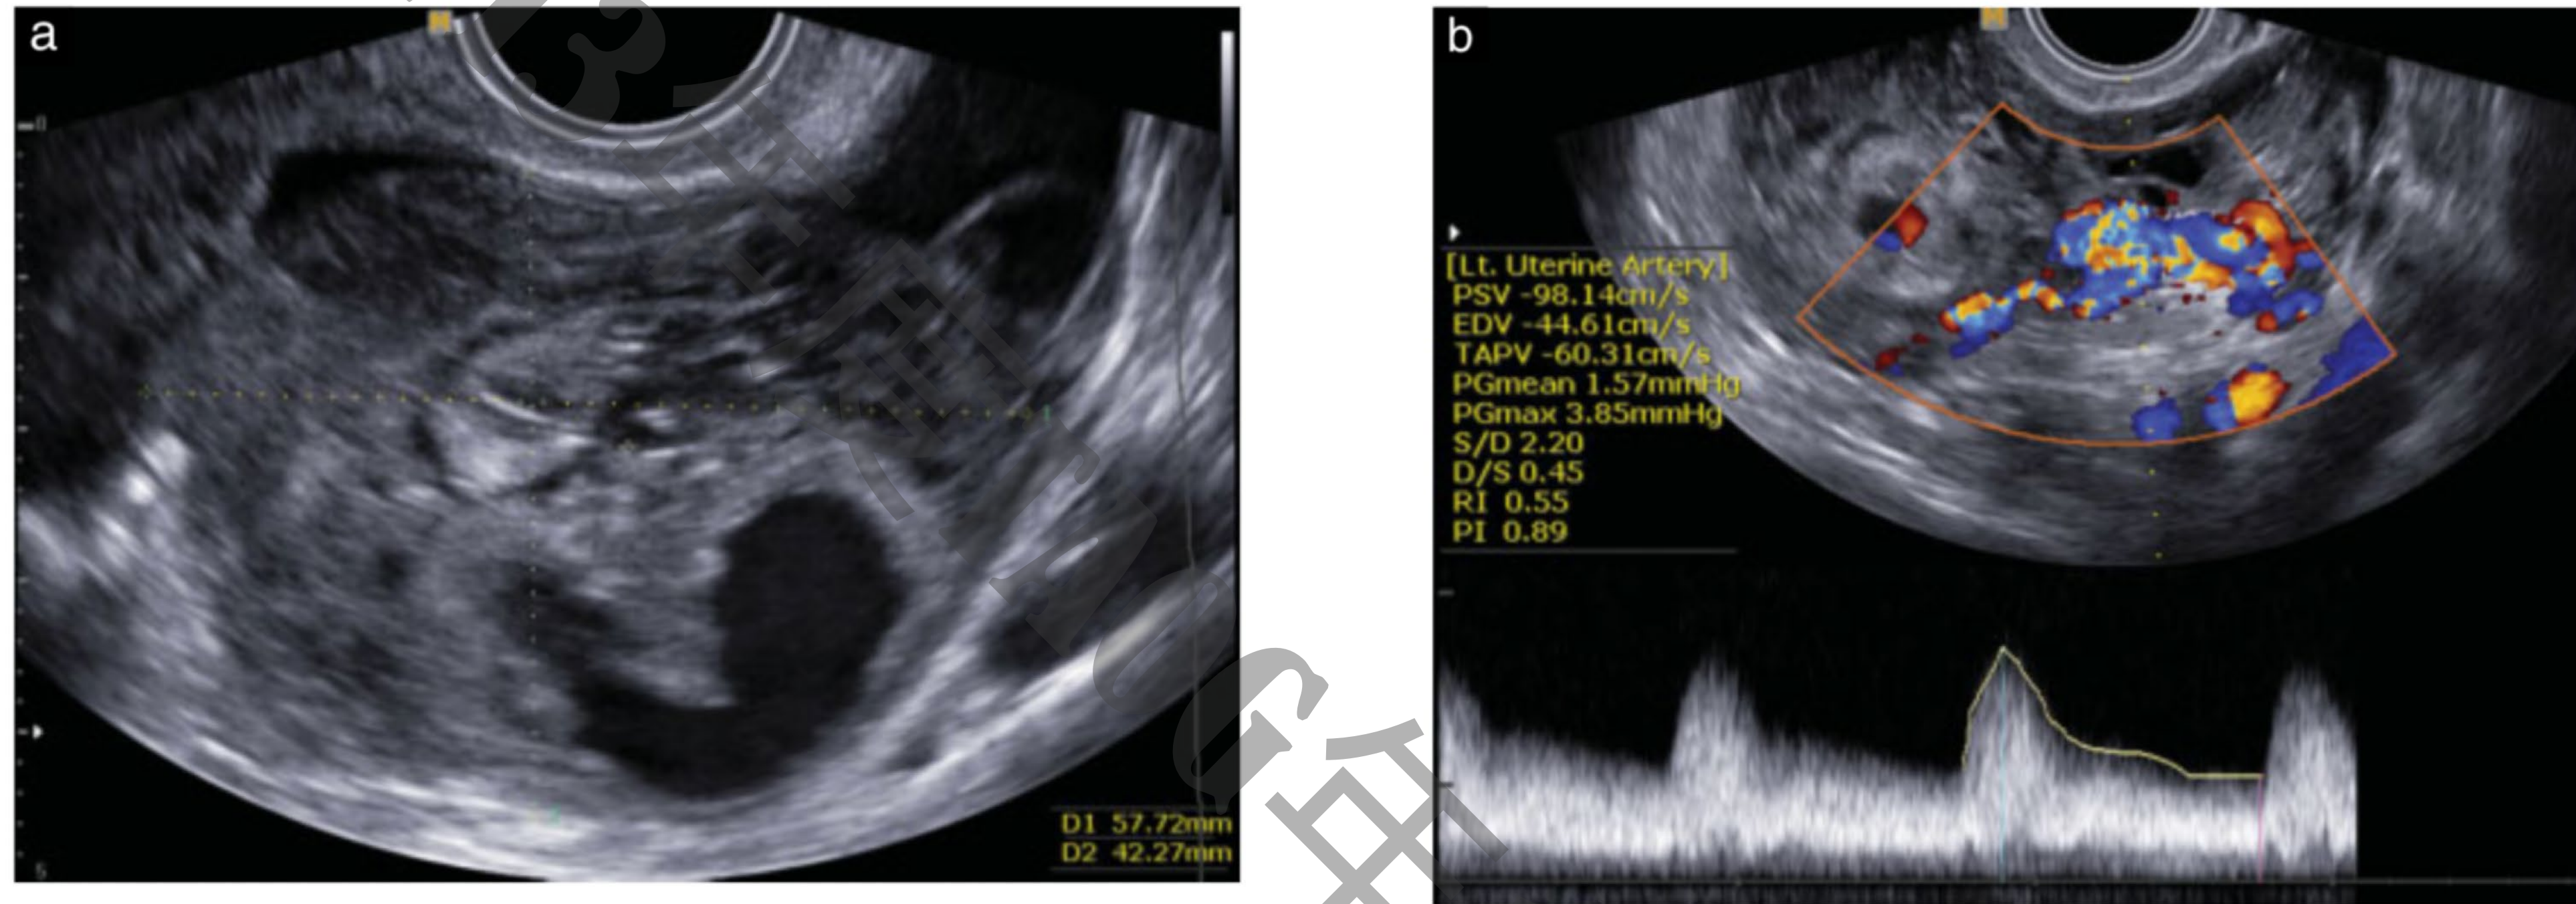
(a) Transvaginal sonographic image in transverse section of the left adnexal site in a 32-year-old woman, showing the presence of an inhomogeneous multilocular solid mass close to the ovary. Note the poorly defined outer borders of the mass and the mixture of anechoic and hyperechoic areas. (b) Transvaginal power Doppler image, showing the presence of a 'nest' of tortuous blood vessels around the mass; on pulsed-wave Doppler, the flow had a high peak systolic velocity and a low resistance index, suggestive of vascular malformation.
